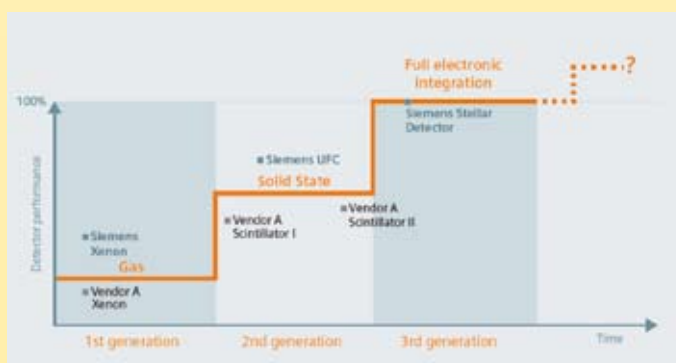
First generation detectors still used Xenon gas under high pressure to convert the incoming X-rays into electric current. Second-generation detectors use solid-state ceramic scintillators to convert X-rays into light, photodiodes to convert the light into current, and analog-to-digital converters (ADC) to digitize the signal. The Stellar Detector is the first third-generation detector that combines the photodiode and the ADC in one Application-Specific Integrated Circuit (ASIC), dramatically reducing electronic noise, power consumption, and heat dissipation.
